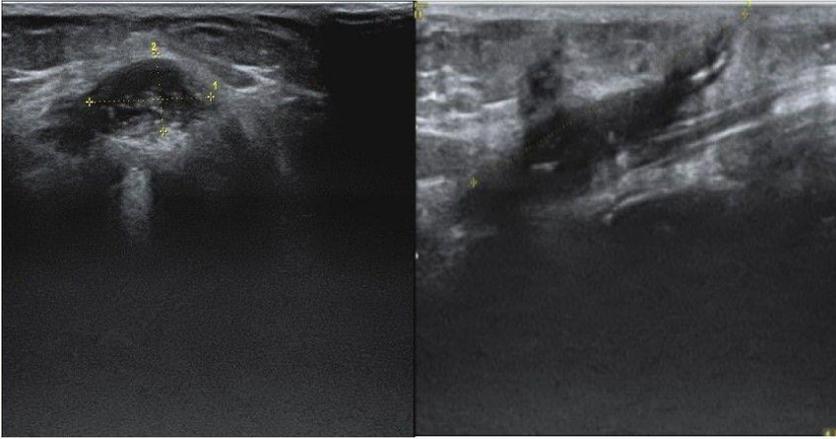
Multinodular goiter and fistulized thyroglossal cyst ultrasonography image
